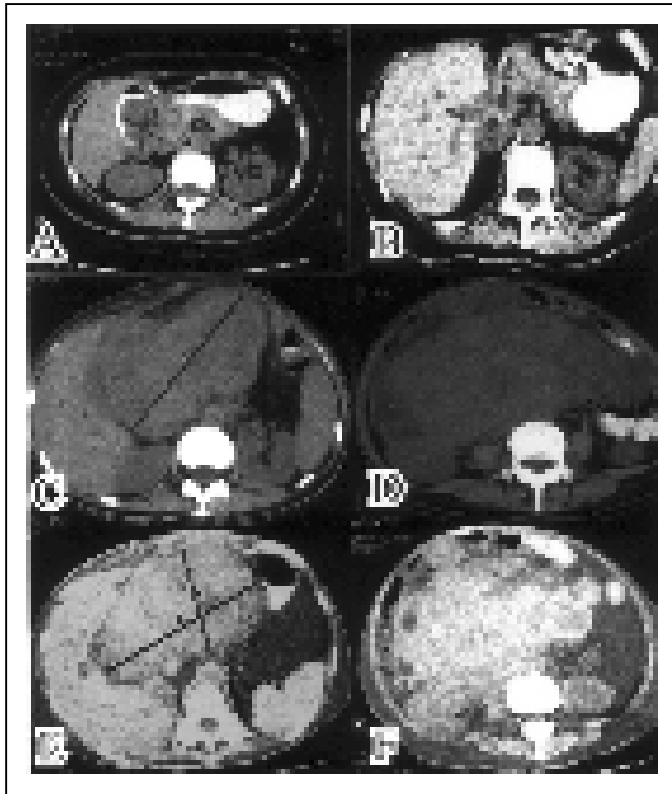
The 45 y/o woman went to doctors due to tarry stool for 10 days. CT study showed a duodenal tumor (A: Mar. 20, 1997). The tumor was 7.1 x 5.3 x 4.2 cm<sup>3</sup> in size. Recurrence happened after the first surgery (B: May 13, 1998, the 14th month) and debulking (C,D: Apr. 20, 2001, the 49th month). The big recurrent tumors had no response to 54 days' glivec therapy (E,F: Jul. 13, 2001, the 52th month). She died on Jul. 19, 2001, the 60th day after her first glivec therapy.
